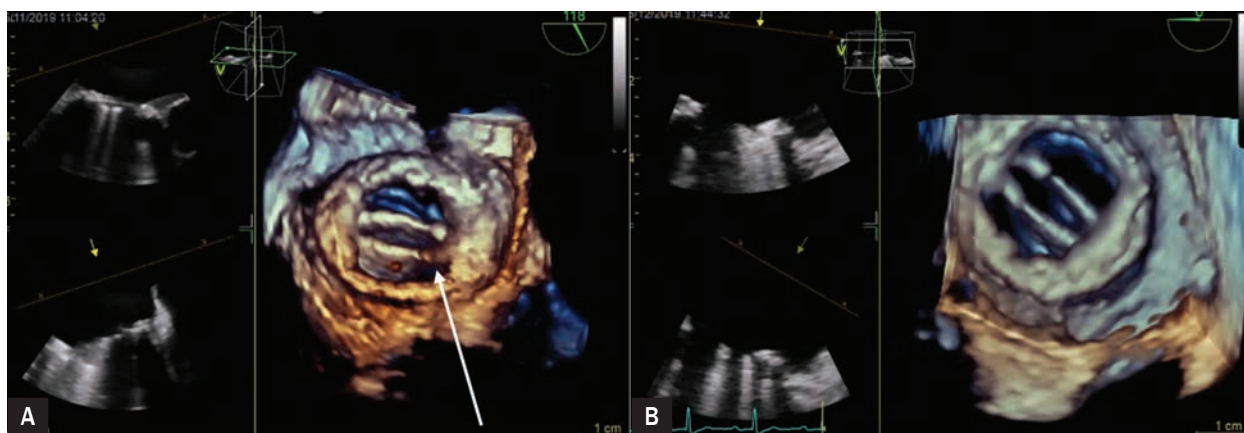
Results of transoesophageal echocardiography: A. At admission, vegetation visualised in 3D imaging; B. Two weeks later, no vegetation visualised in 3D imaging
